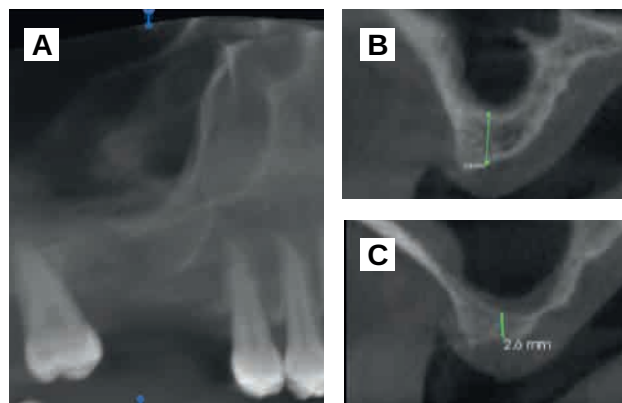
A. Pre-op CBCT. B. Residual height of 5.0 mm at 1.6. C. Residual height of 2.6 mm at 1.7.
